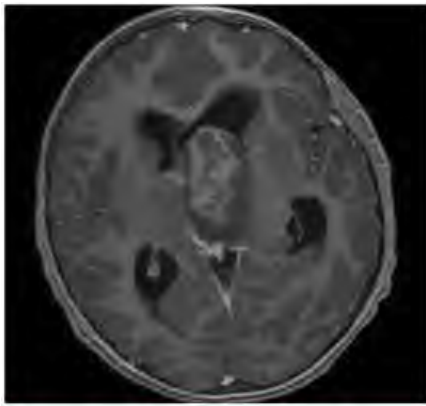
Axial T1-weighted C+ image showing large heterogeneously enhancing mass arising from the left thalamus.
